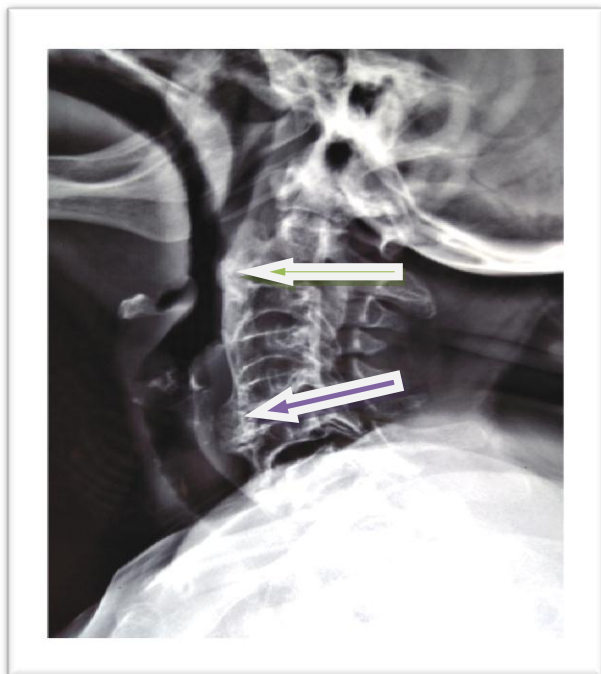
Soft tissue X-ray of the neck, in lateral view, showing large anterior osteophytes (green arrow) of the C2 and C3 vertebral bodies and another large elongated osteophyte of C5, C6 vertebral bodies (blue arrow) causing compression of pharynx and esophagus respectively.
